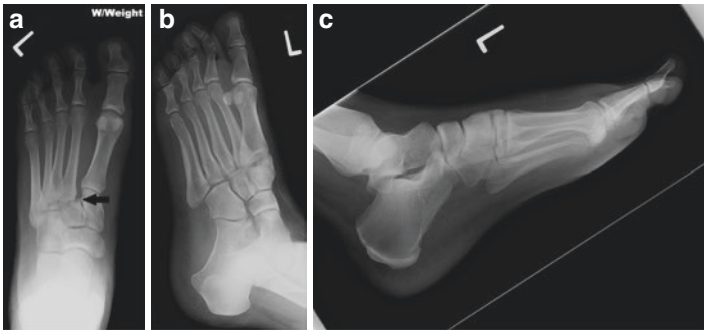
Radiographs of the patient's left foot taken 3 days after the injury. (a) Weight-bearing AP view showing  $>2$  mm diastasis of the first intermetatarsal space and loss of alignment between the medial borders of the middle cuneiform and the base of the second metatarsal. The arrow is showing the *fleck sign*: an avulsion of the Lisfranc ligament from the base of the second metatarsal. (b) Oblique view shows congruent third and fourth TMT joints. (c) Lateral view showing no dorsal or plantar displacements
